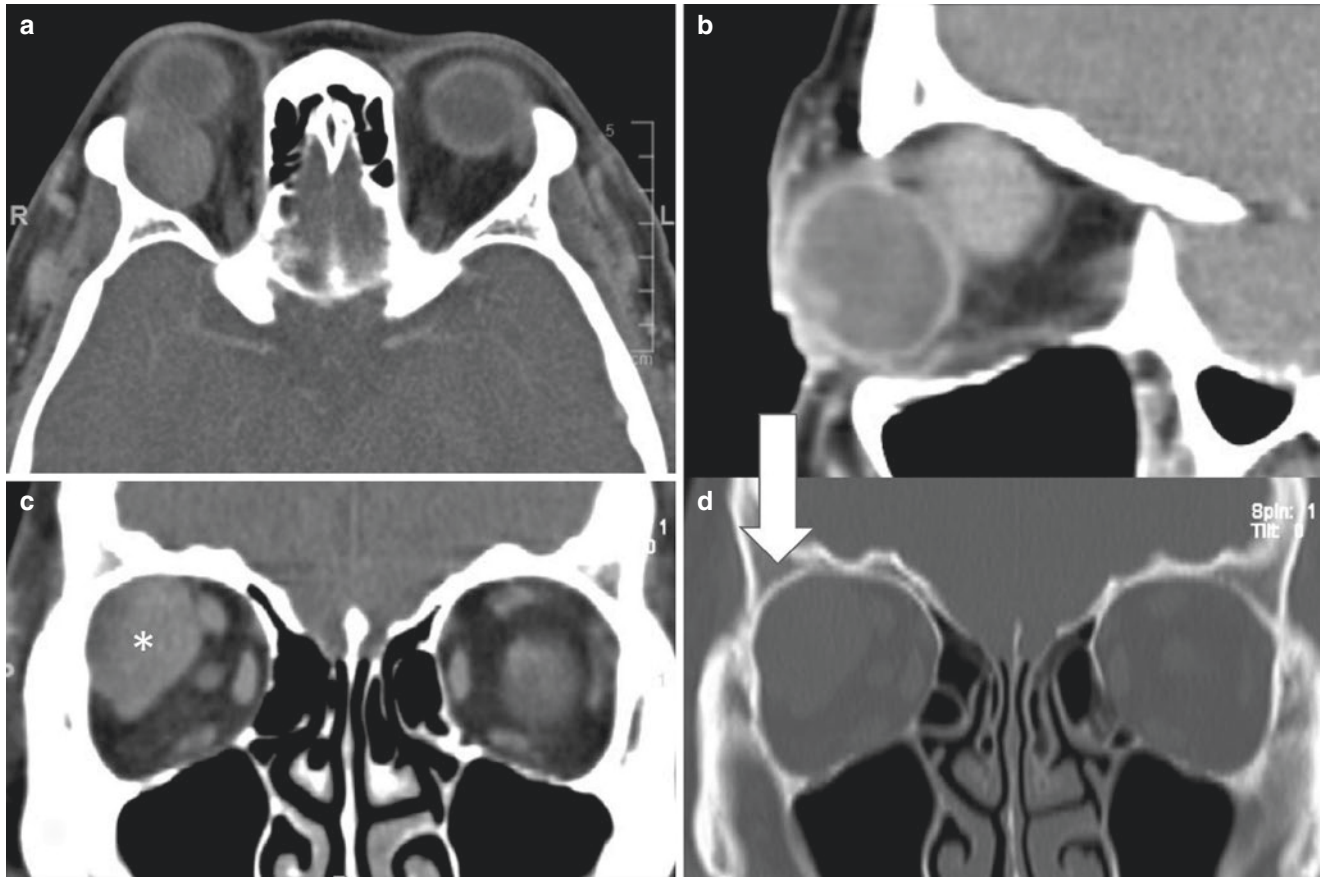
(a, b, and c) Axial, sagittal and coronal CT scans showing a solid mass (*) in the right lacrimal gland fossa with uniform density and enhancement. (d) Coronal bone window shows remodelling of the superolateral wall of the right orbit adjacent to the mass (arrow)
